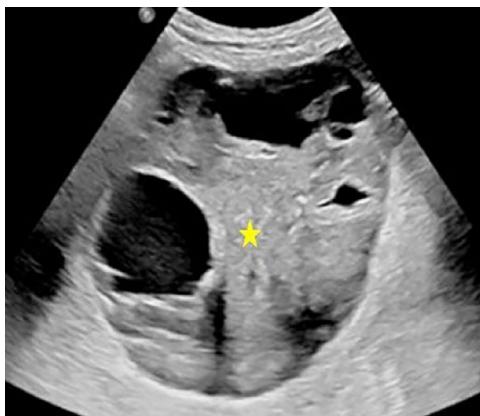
Pelvic ultrasound reveals a large, well-defined and heterogeneous mass (★) with a cystic and solid component.
